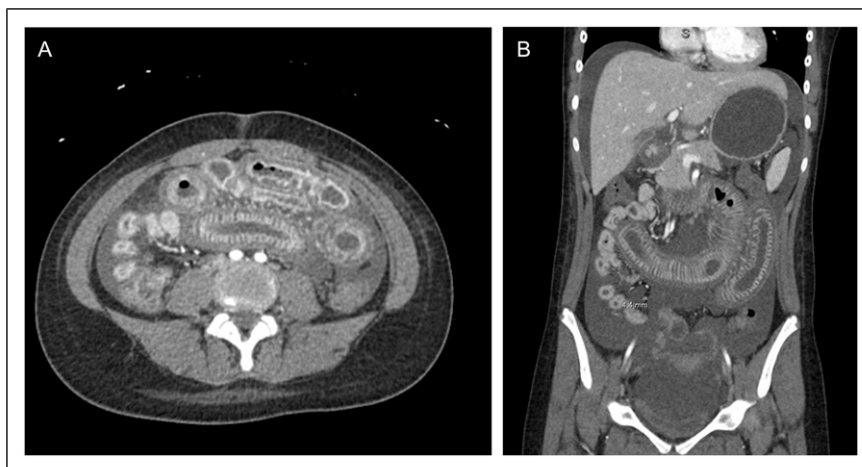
CT abdomen and pelvis. (A) Axial and (B) coronal views demonstrating extensive bowel wall thickening and edema primarily involving the proximal small bowel.
